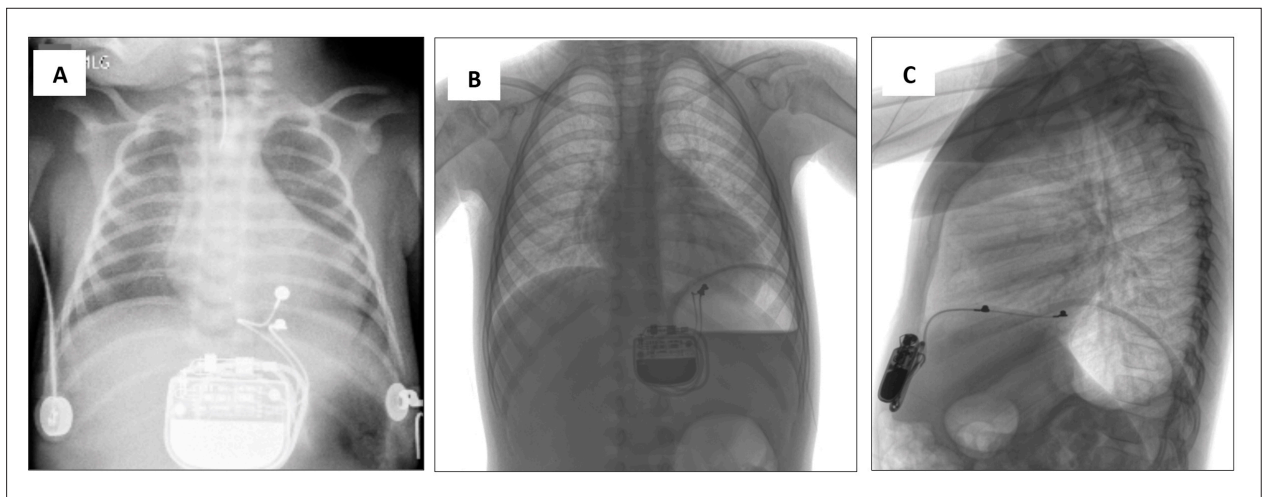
Chest radiographic projections displaying the radiologic appearance of epicardial pacemaker implantation immediately after the procedure (A) and 3 years later, in anteroposterior (B) and lateral projections (C).
